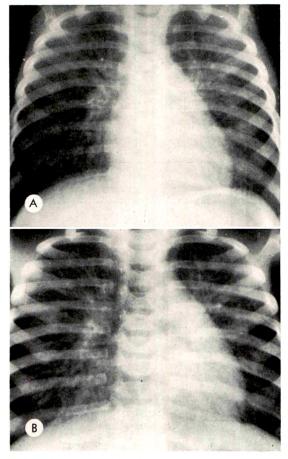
Case II. (A) Posteroanterior chest roentgenogram. A coarse nodular infiltrate fans out from each hilar area. (B) A repeat roentgenogram 5 days later demonstrates some coalescence of the infiltrates and localized emphysema.
